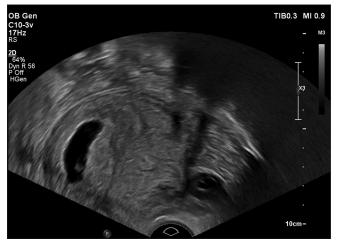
Transvaginal ultrasonography of an intrauterine gestation (left) coexisting with an ectopic gestational sac as an adnexal mass with fluid echo (right) before treatment
